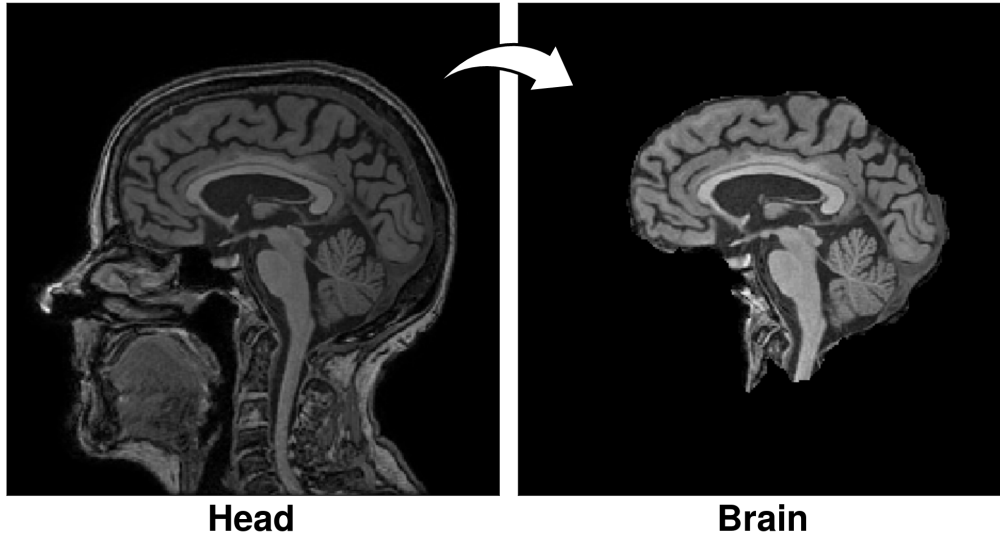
On the left we have a full head MRI image that we can verify has a lot of unnecessary tissues. We can simplify the image before processing by removing the unwanted tissues and leaving only the brain like shown on the right.
